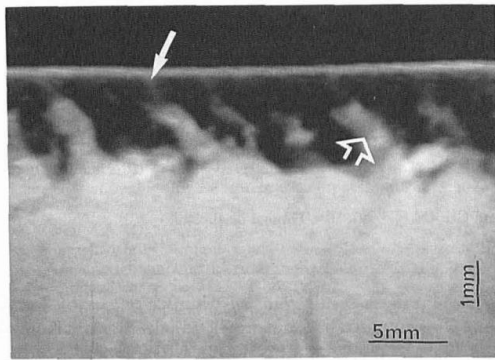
(Left) T2-weighted In vivo MRI of skin on thigh. The outer bright thin layer corresponds to the epidermis. Dermis appears as a darker layer. Hypodermis appears as a homogenous bright area. (Right) Proton densities associated with young and old subjects [49]
